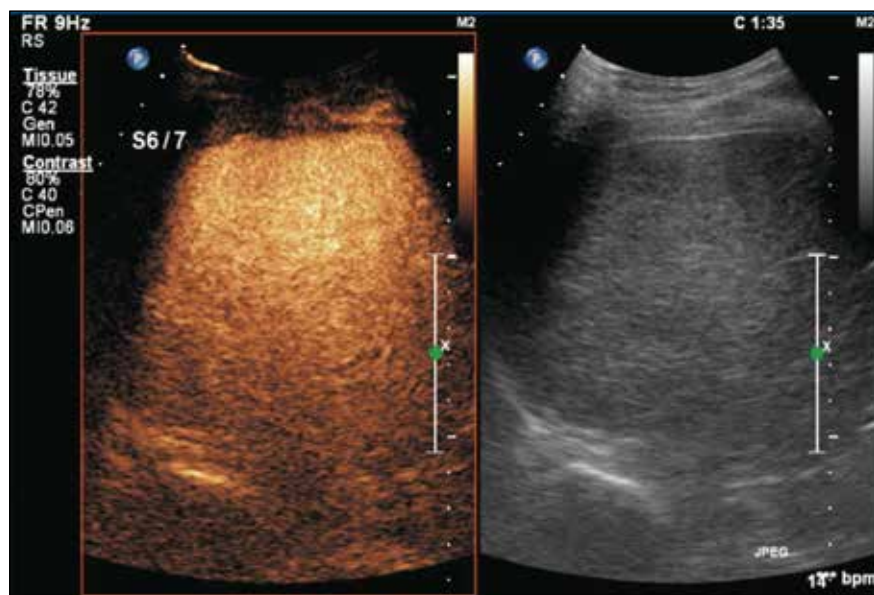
Dual-screen display with contrast-mode image on the left and low mechanical index B-mode (brightness mode) ultrasound image on the right side-by-side when performing contrast-enhanced ultrasound. A scanner timer is also displayed at the upper right corner of the screen.
